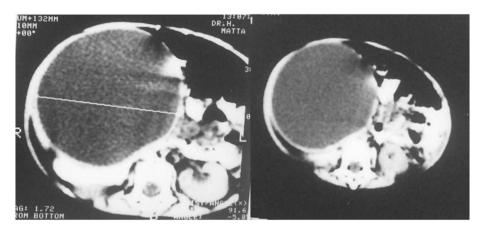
A and B: Abdominal CT-scan showing a large right-sided abdominal cystic swelling.
